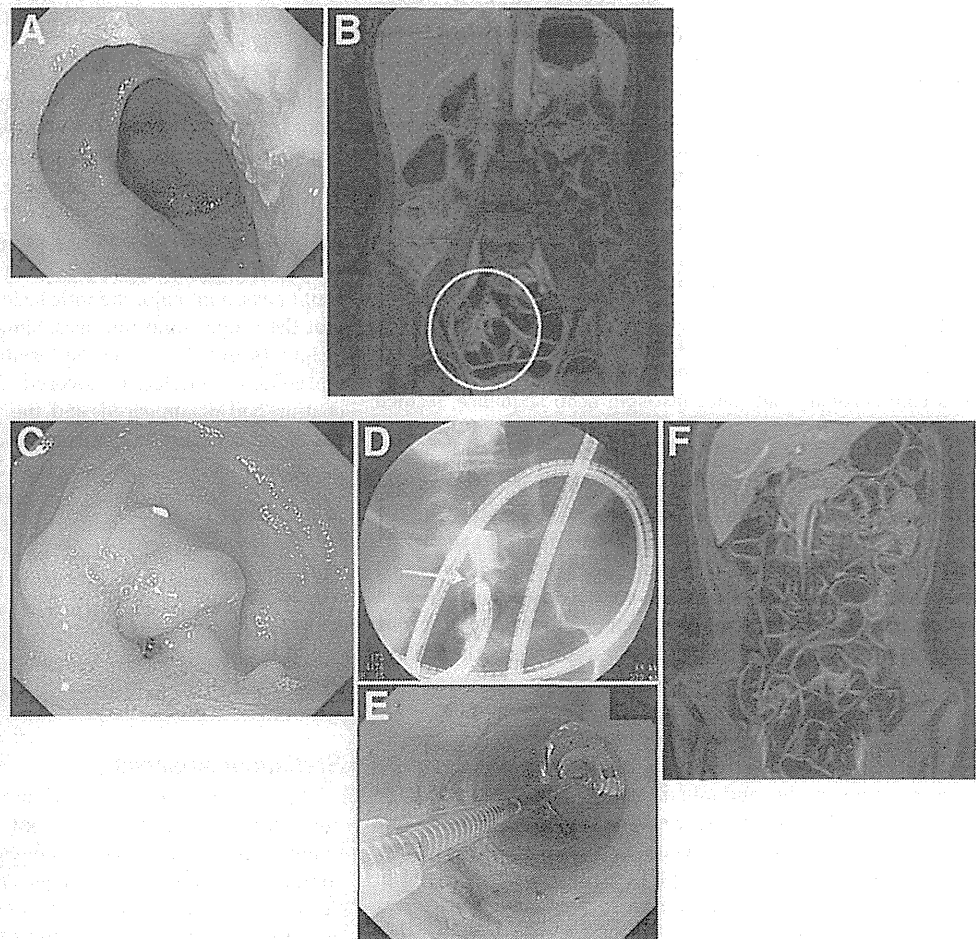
An example of comparison between enteroscopy and MREC for ULs and major stenoses. (A) Enteroscopy detected ULs in the proximal ileum. (B) MREC with 3-dimensional T1-weighted contrast-enhanced GRE sequence also detected it in the same segment as wall thickening and increased contrast enhancement (yellow circle). (C) In contrast, enteroscopy detected major stenosis that the scope could not pass in the proximal ileum. (D) The length of stenosis (yellow arrow) was 1 cm, and (E) balloon dilatation was performed. (F) However, MREC with any sequence could not detect this stenosis.
